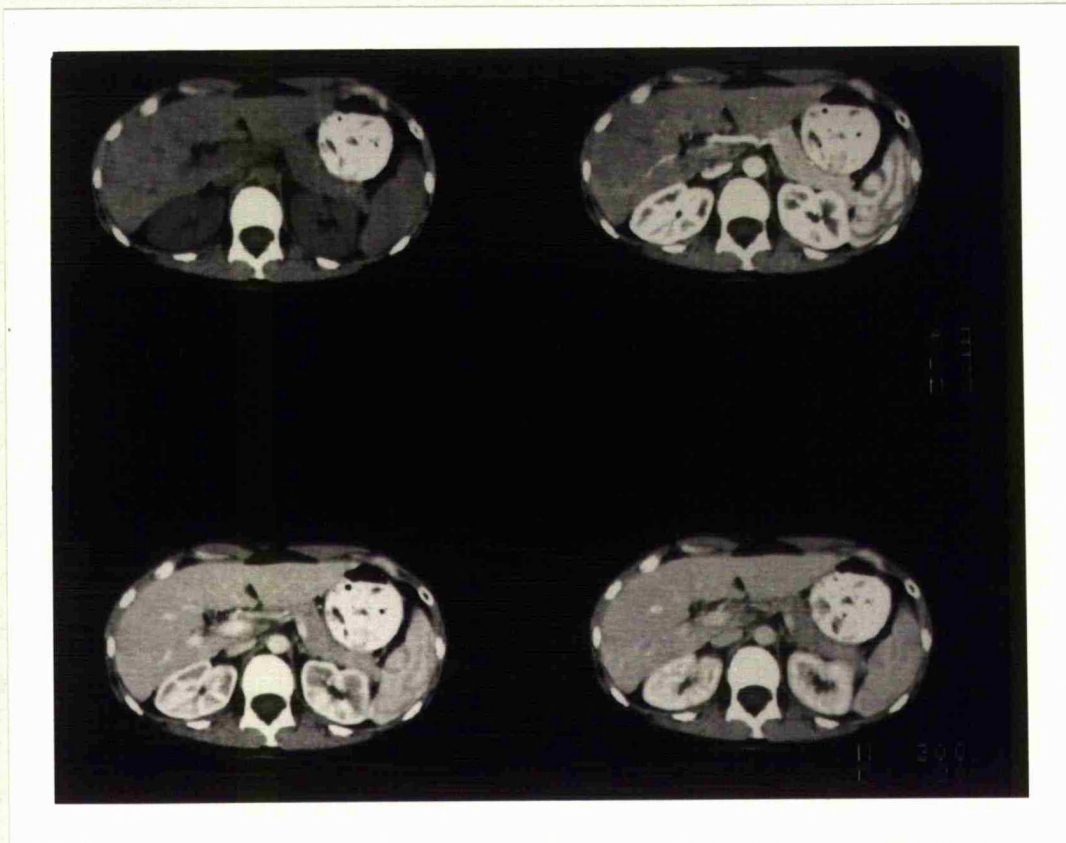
Conventional CT images from a single location dynamic sequence demonstrating dramatic regional variations in splenic enhancement.
